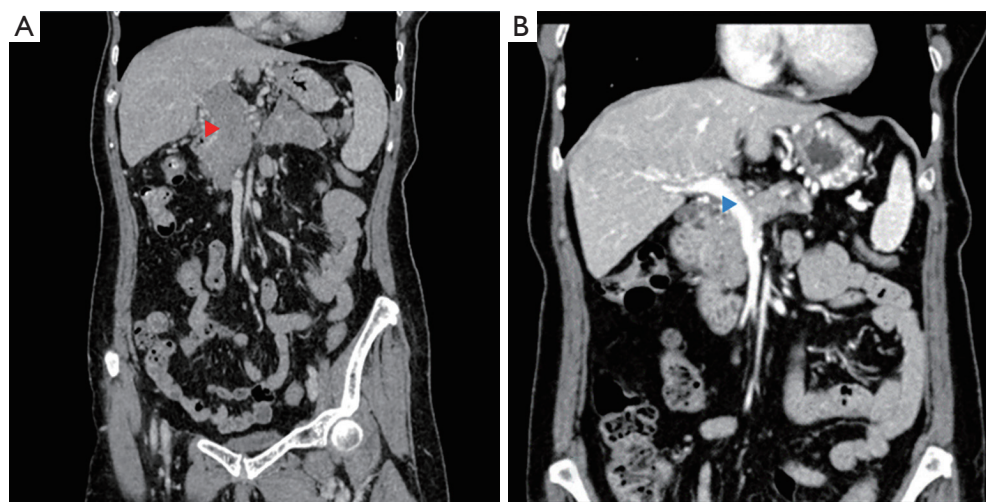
Comparison of contrast-enhanced CT images before and after neoadjuvant chemotherapy. (A) Before chemotherapy, red triangle: PV system filled with tumor thrombus. (B) After chemotherapy, blue triangle: PV-SMV is mostly patent, with a significant reduction in the size of the tumor thrombus compared to before. CT, computed tomography; PV, portal vein; SMV, superior mesenteric vein.
